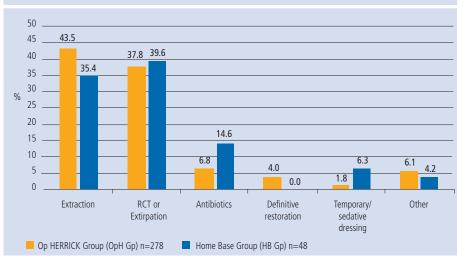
Treatment of teeth with pulpitis or periapical infection causing pain lasting >60 minutes
